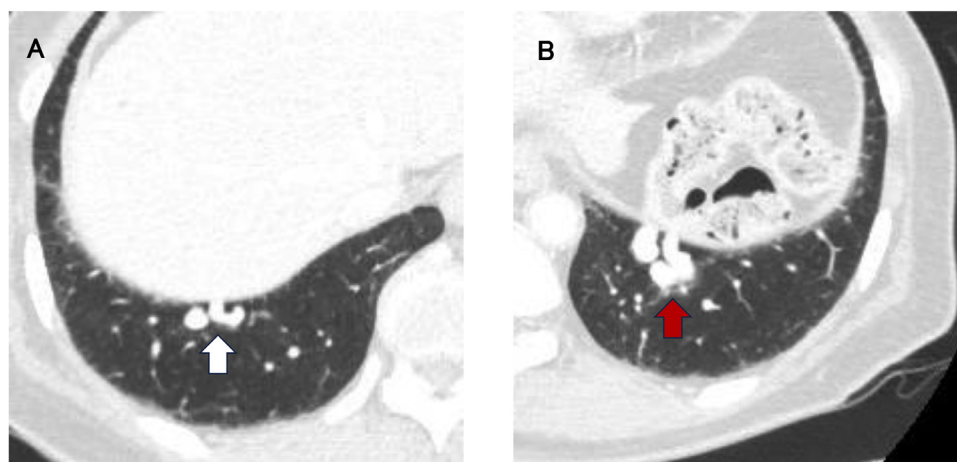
Axial computed tomography images of the chest at the first visit. (A) Abnormally dilated vessels are shown in the right lower lobe (white arrow). (B) Similar abnormal vessels are shown in the left lower lobe (red arrow).
